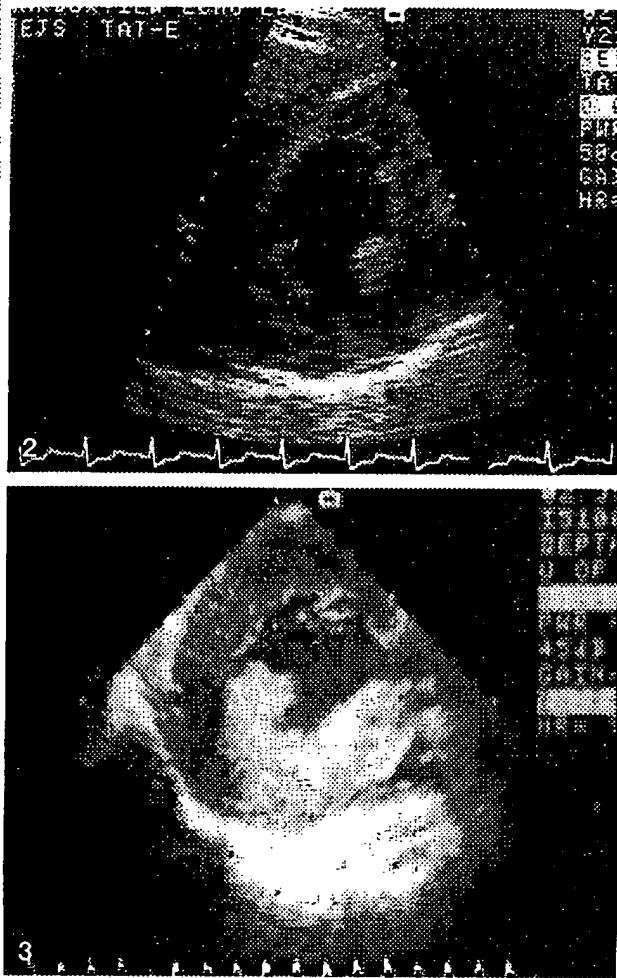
Parasternal short axis view of the donor left ventricle taken prior to explantation. There is concentric left ventricular hypertrophy (15 mm)
